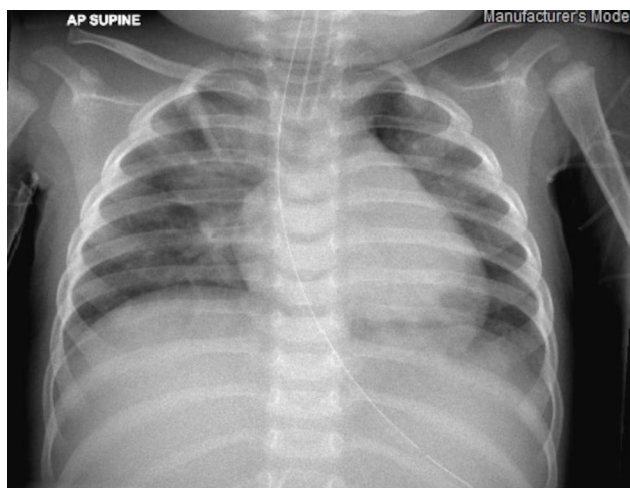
Chest X-ray showing bilateral lung consolidation likely due to aspiration pneumonia
